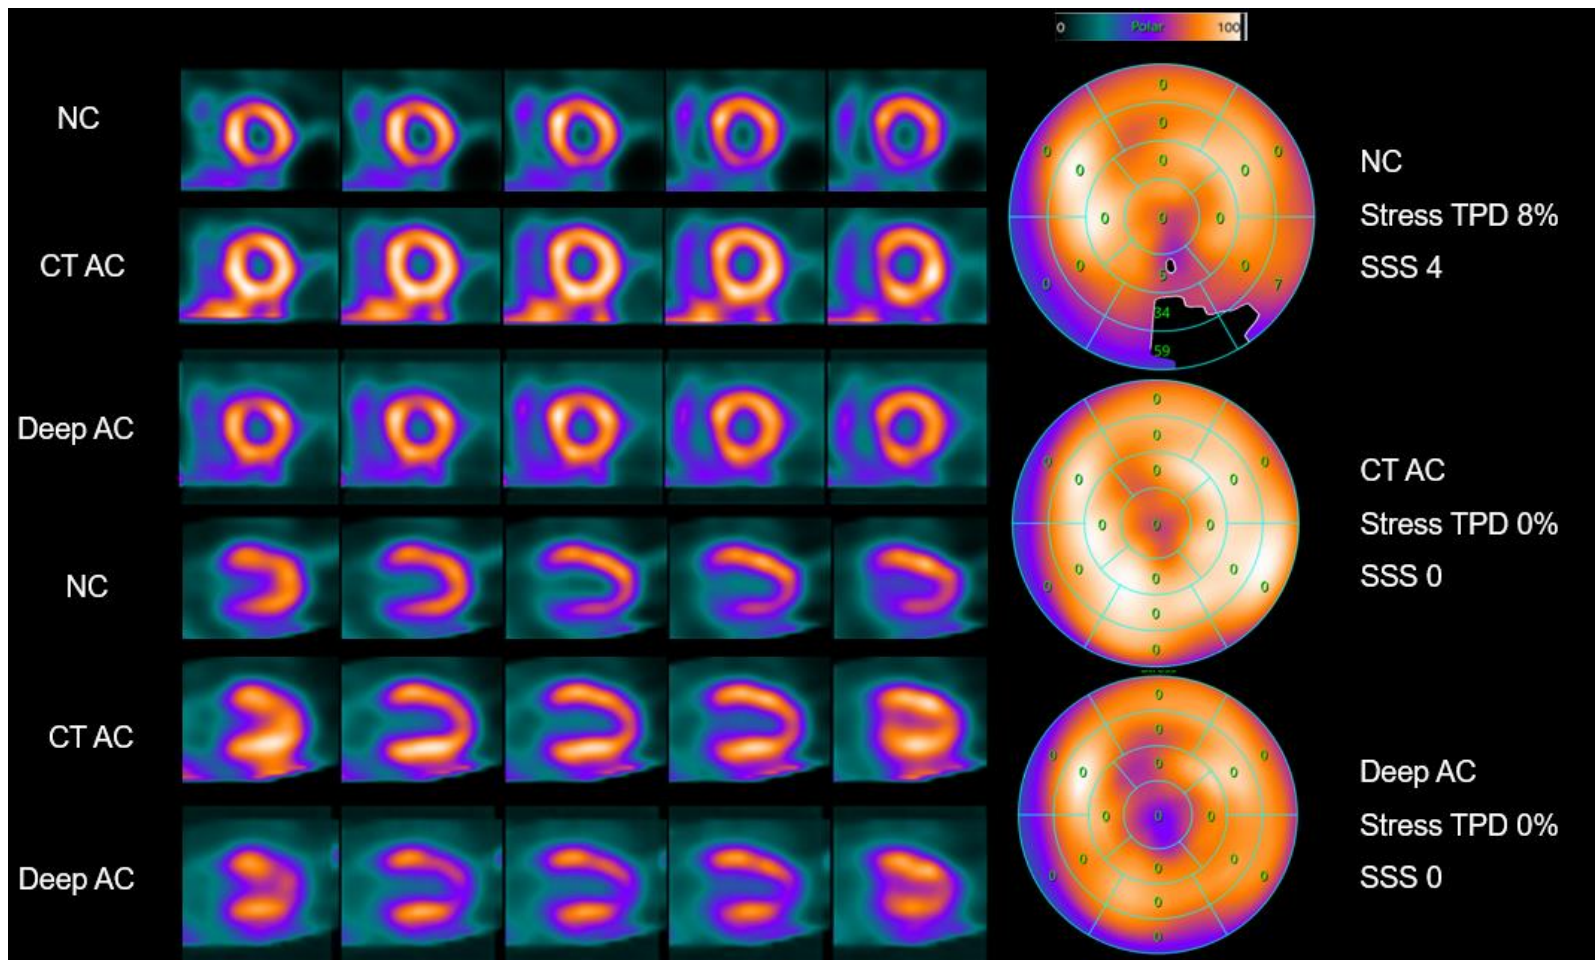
Case example from External Population 2 with CT Attenuation Correction. A 57-year-old female patient with high body mass index of 38 kg/m². Non attenuation correction (NC) total perfusion deficit (TPD) was abnormal at 8% and clinical summed stress score was 4. Both computed tomography (CT) attenuation correction (AC) images and DeepAC images demonstrated minimal perfusion abnormalities (stress TPD 0%, summed stress score [SSS] 0).
